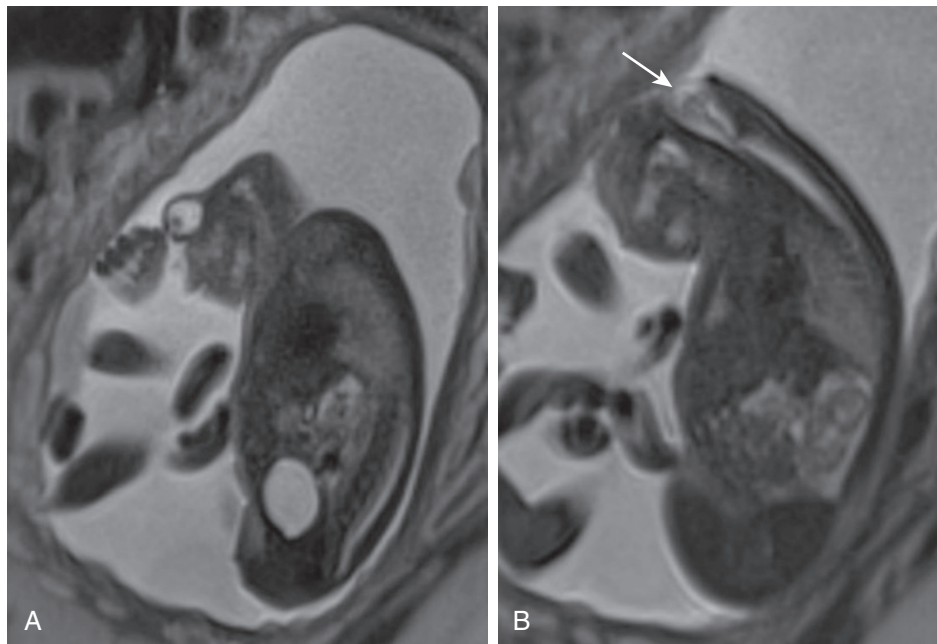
Fetal magnetic resonance imaging showing anencephaly. Note abrupt ending of brain parenchyma at the rostral end of the rudimentary brain stem (arrow).
